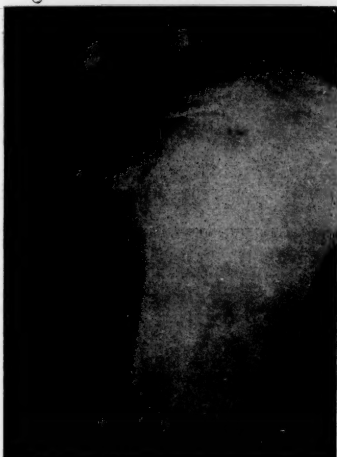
M. O. S. X-ray taken on admission, September 15, 1926. Dense shadow shows calcification of the subdeltoid bursa.
